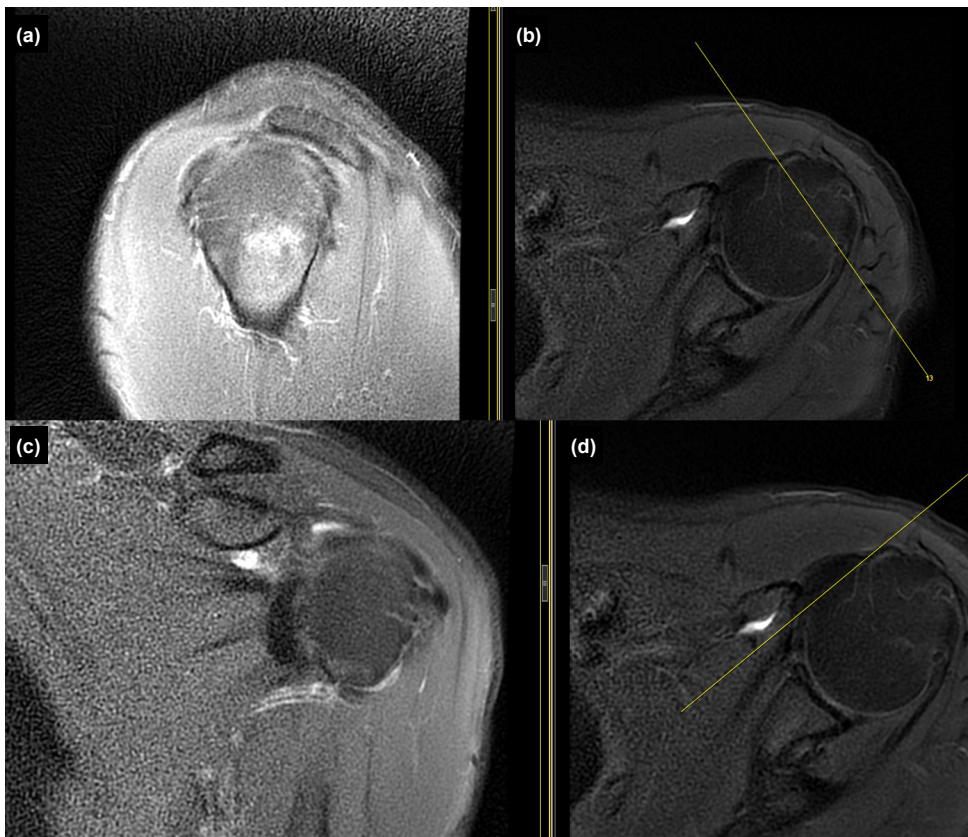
Axial, coronal, and sagittal magnetic resonance imaging (MRI) sections demonstrating the absence of the intra-articular portion of the long head of the biceps tendon.
